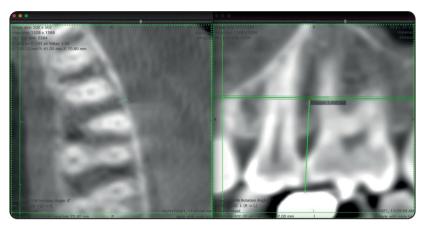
Measurement of alveolar buccal cortical bone thickness on CBCT scan.
